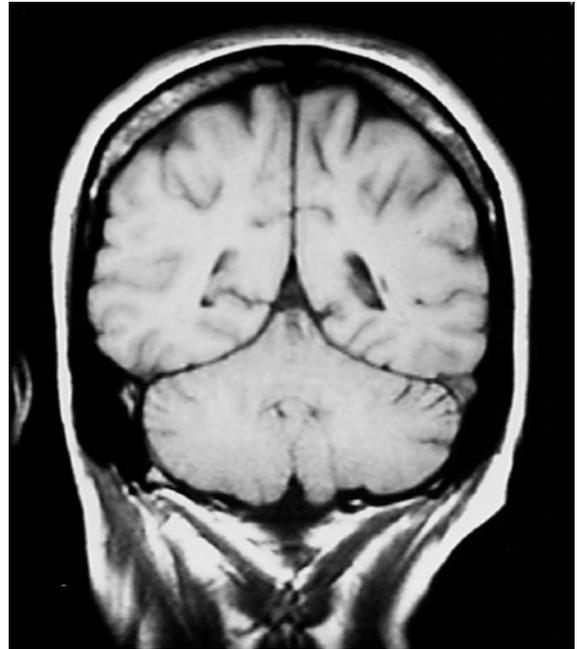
MRI Scan of the brain through the occipito-temporal gyri. The cerebellum lies inferior to the occipital lobe and is separated by the tentorium cerebelli.
